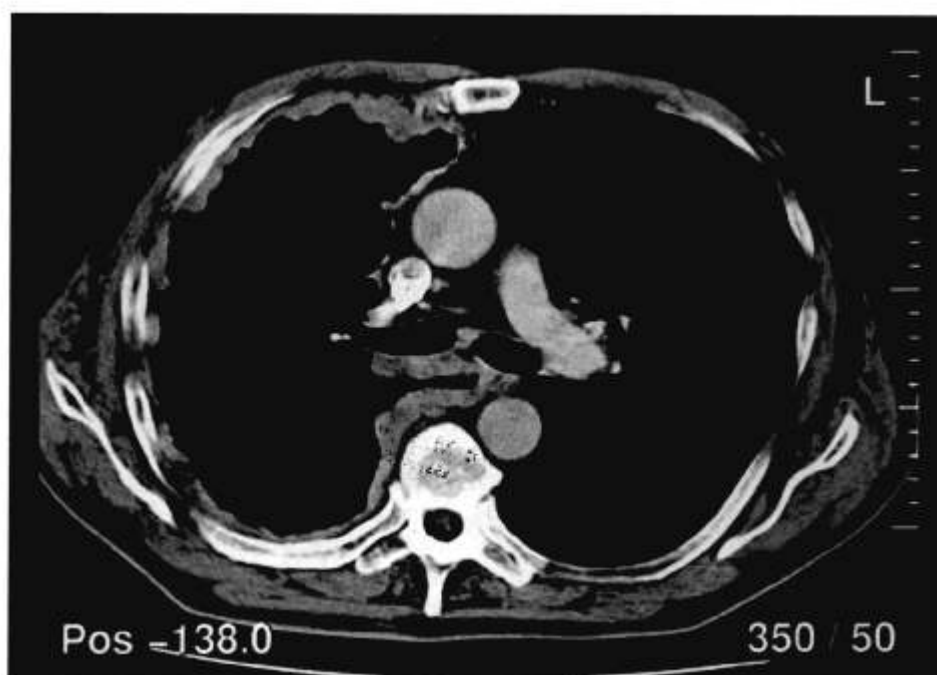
Contrast-enhanced chest CT in the corresponding slice position to Figure 1. After application of seven cycles of chemotherapy with gemcitabine the tumor had shrunk to approximately 50% of the initial volume.
